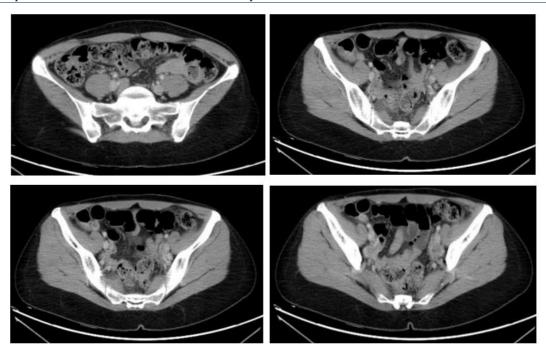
CT Scan abdomen pelvis, transversal view, showing thickened enhancing wall dilated appendix.
